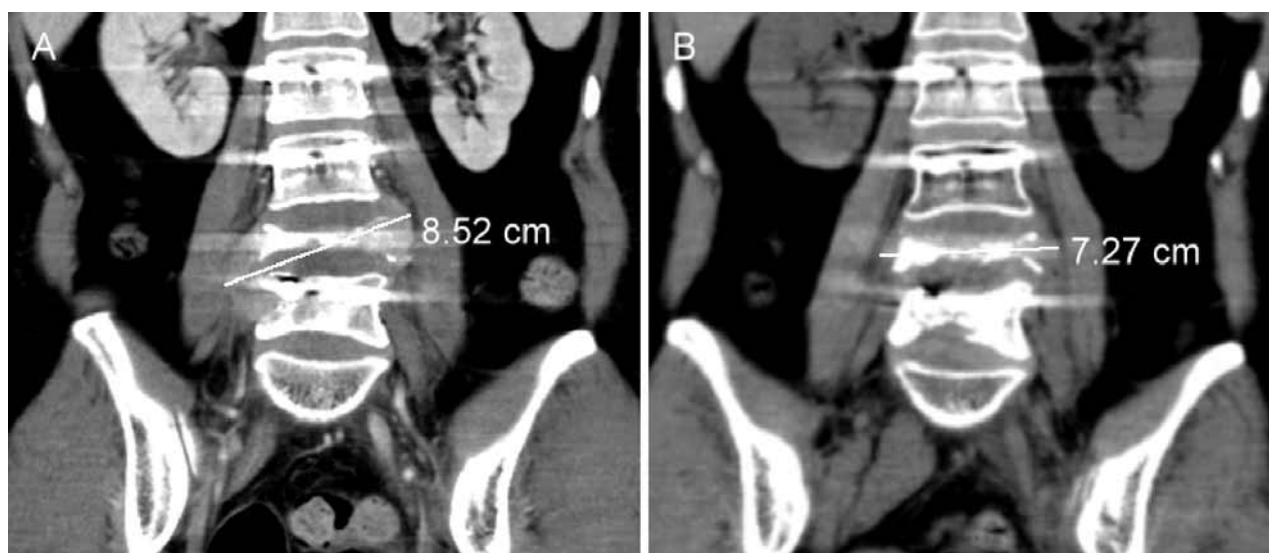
CT films obtained before (A) and after (B) five cycles of chemotherapy with carboplatin and bevacizumab. The lesion is smaller but remains a stable disease after the treatment.
